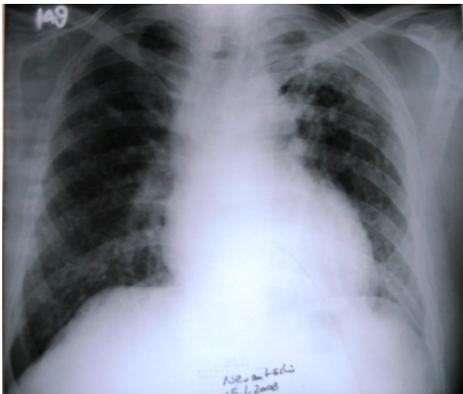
Number 3 technician's chest X-ray.
